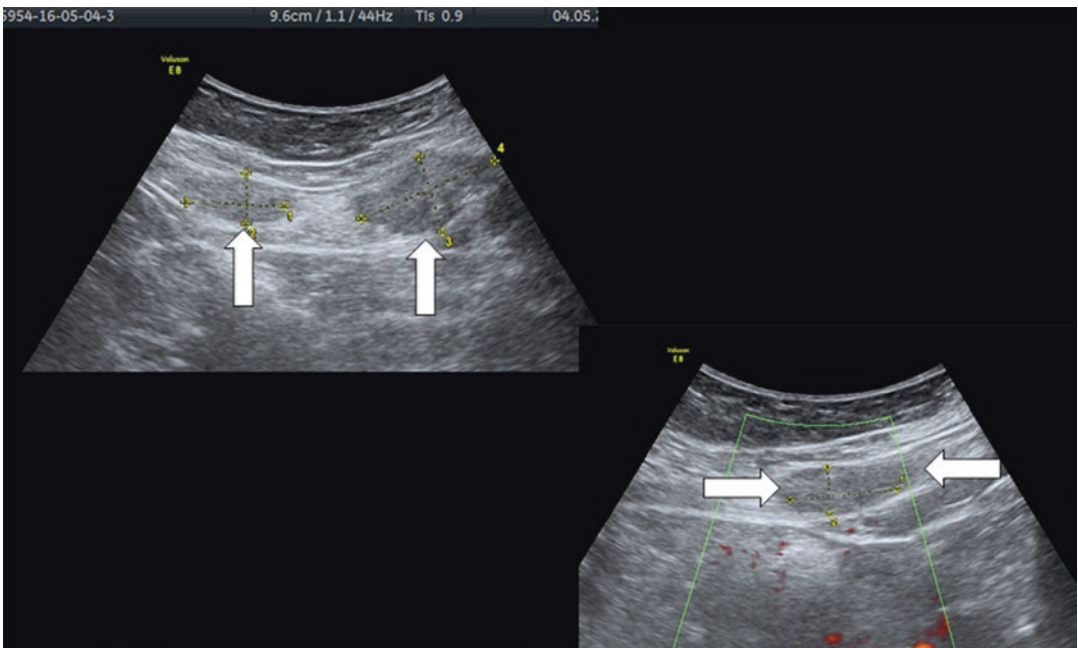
Ultrasonographic images of two nodules of scar endometriosis (*straight arrows*) in a 39-year-old woman with a previous cesarean section 6 years before
